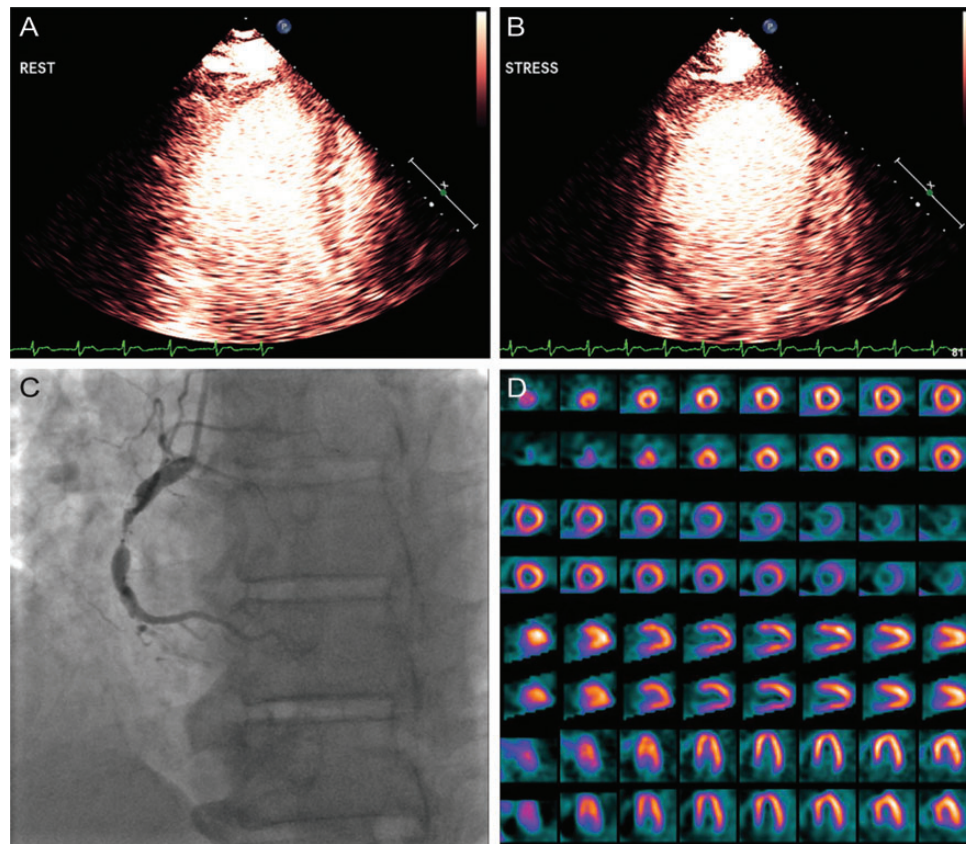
A 52-year-old man with significant reversible defect of the inferior wall shown by myocardial contrast echocardiography at rest (A) and under stress (B), corresponding to an 80% stenosis of the right coronary artery on quantitative coronary angiography (C). SPECT (D) revealed no abnormalities. From Senior *et al.*³ with permission from the journal.
